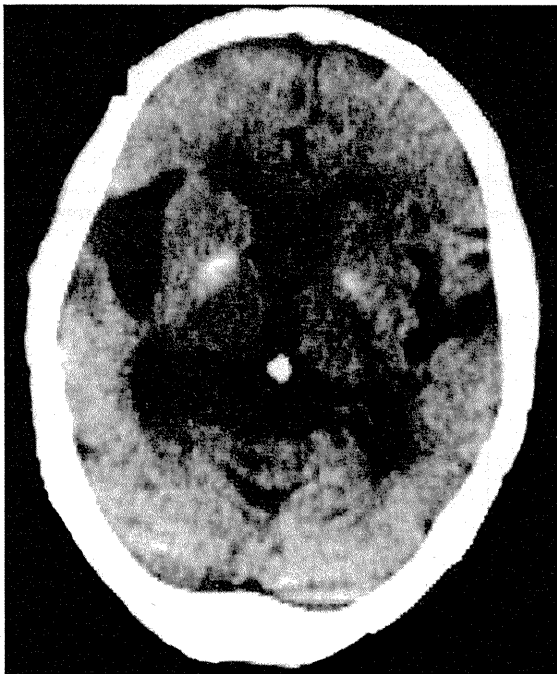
Computed tomography of the brain showing bilateral atrophy of the frontal and temporal lobes with pallidum calcification (Case 8).
